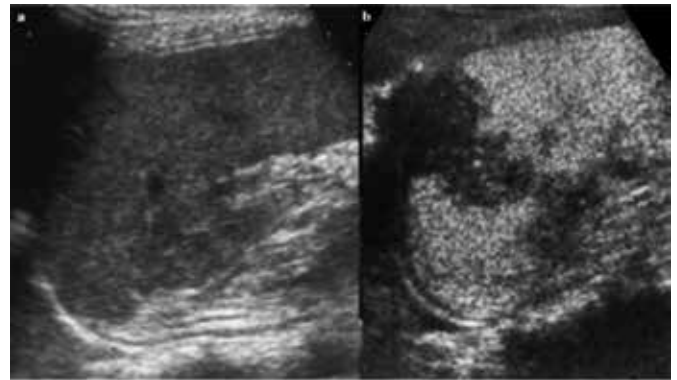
Contrast ultrasound of splenic trauma. In “a” longitudinal sonography and in “b”, a hypoechoic lesion<sup>12</sup>.
